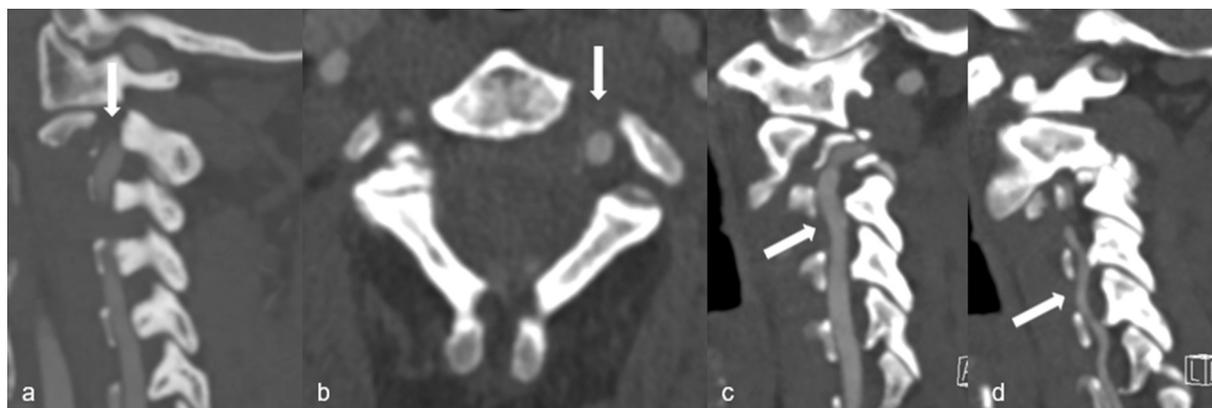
CT-angiography of Case 2 in (a) sagittal and (b) axial view, with the arrow pointing at the vertebral artery running inside the fracture gap and (c) sagittal view, showing the left vertebral artery and (d) showing the hypoplastic right vertebral artery, both indicated with arrows.
